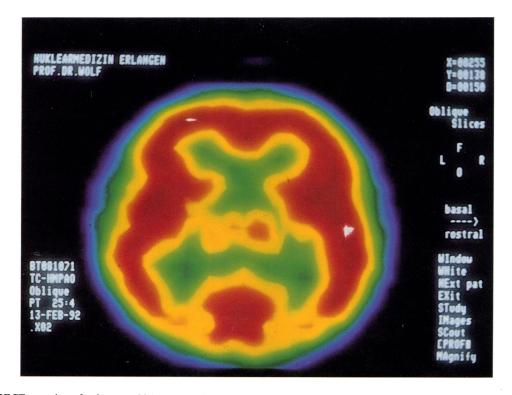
SPECT scanning of a 21-year-old homosexual man showing a normal brain perfusion pattern. Anticardiolipin antibodies (ACA) were within the normal range (≤ 20 GPL).
